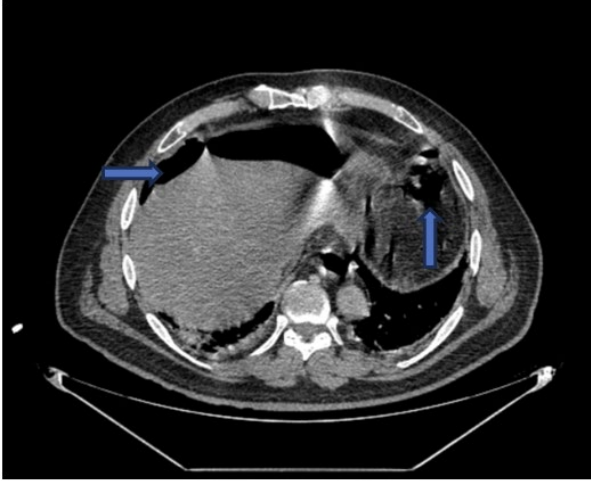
Computed tomography image of free fluid in the abdomen
